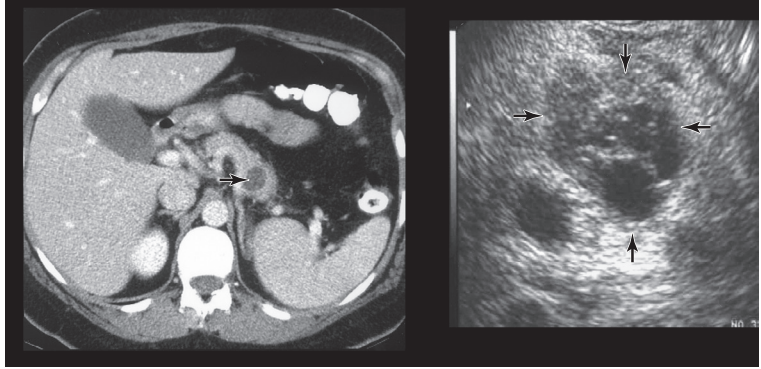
A mucinous cystic neoplasm of the tail of the pancreas. The endoscopic ultrasonogram (right) demonstrates septa and loculations not seen on the computed tomography scan (CT; left) and also allows for sampling of cyst fluid. The arrow on the left panel points to the cystic neoplasm on the CT image, and the arrows on the right image delineate the neoplasm on the ultrasonographic image. (From Feldman M, Friedman L, Brandt L, Sleisenger and Fordtran's gastrointestinal and liver disease. 8th ed. Philadelphia: Saunders, 2006, Fig. 58-11.)
